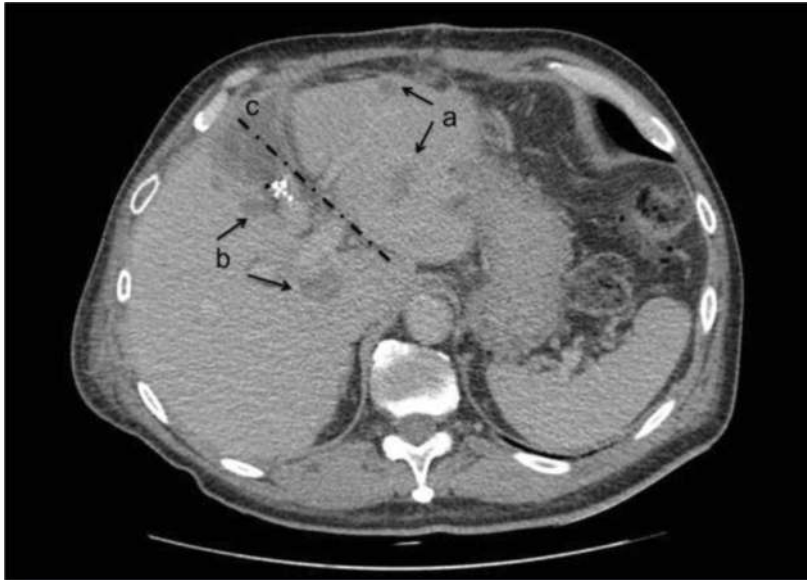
Postoperative CT image of a patient who underwent portal vein ligation and staged hepatectomy: (a) treated liver metastases of the FRL, (b) metastases on liver to be resected, and (c) line of liver bipartition.
